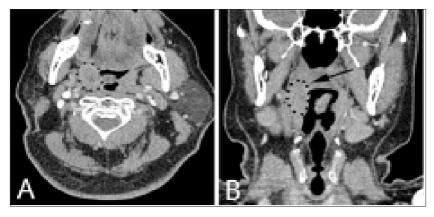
Contrast enhanced computed tomography (CT) of the neck in axial plane at level of palatine tonsils (A) and coronal plane (B) showcasing the mass (black arrows) with its margins outlined by dotted lines. On this axial image, subtle hypodense core was observed within said mass probably representing necrotic soft tissue centrally. The normal left palatine tonsil can be identified on both images. Anteriorly and posteriorly, the mass abutted the right tongue base and the prevertebral space respectively. No significant effacement of ipsilateral parapharyngeal space was seen. No vascular encasement of the right carotid sheath was indicated. The coronal image (B) showed part of the right soft palate is involved
